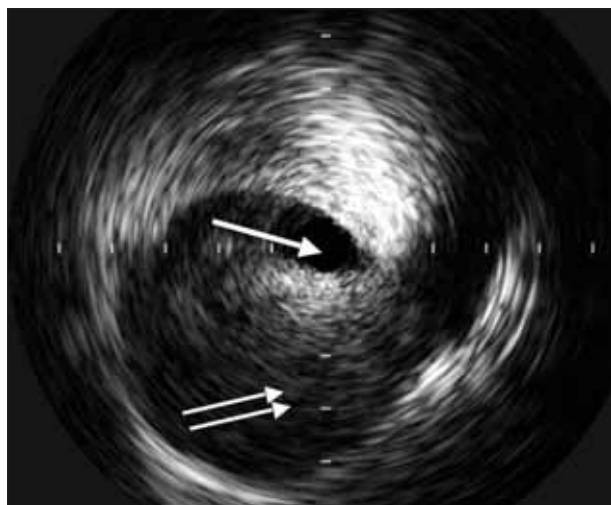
IVUS image shows the severely compromised true lumen at the level of the superior mesenteric artery (arrow) and sluggish flow in the false lumen where it appeared to be thrombosed on CT and on contrast angiography (double arrows).
